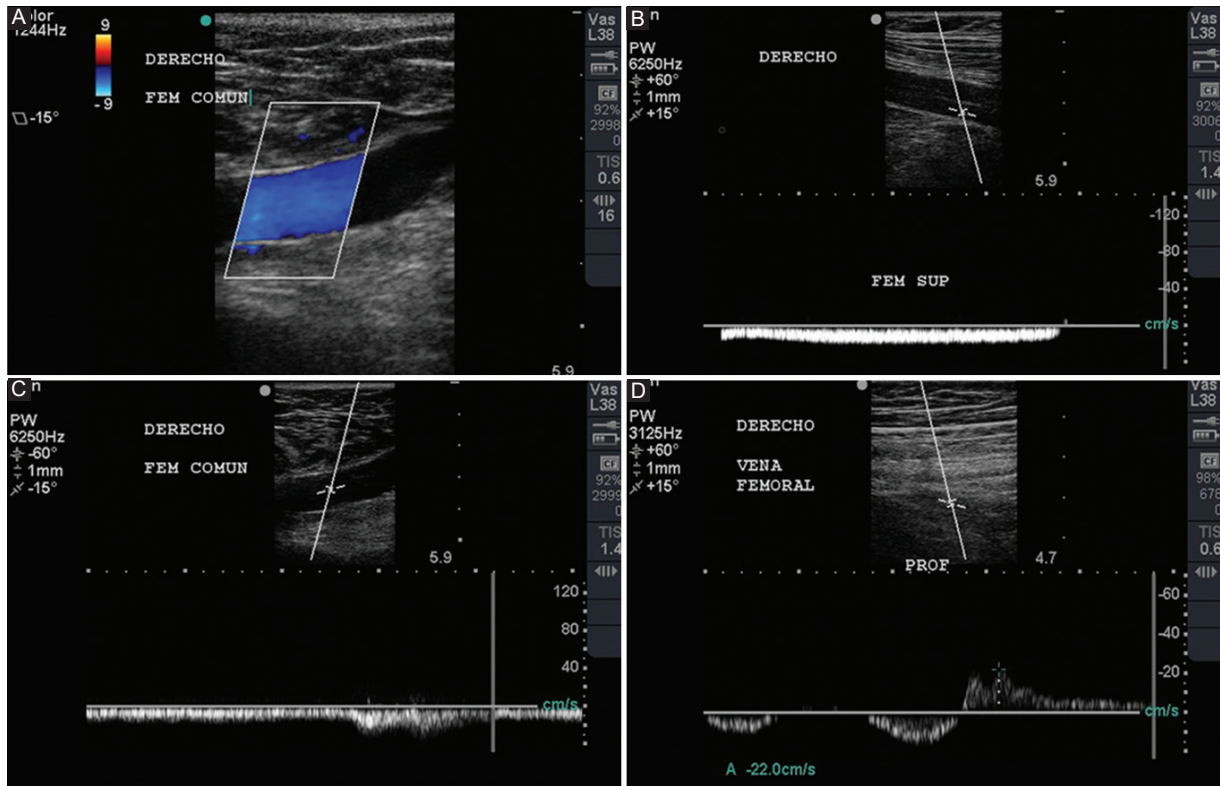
A: doppler signal with normal color; homogeneous signal with complete filling of the light of the common femoral vein, which represents permeability. B: normal pulse Doppler spectrum; the Doppler spectrum can be seen, which is respiratory phasic, below the baseline, with a small peak above the baseline due to adequate valve closure, without reflux during the Valsalva maneuver. C: muscle systole response; during the muscle systole an increase in the spectrum can be seen, without delimiting the flow, showing distal permeability with no insufficiency data. D: doppler spectrum above the baseline during the Valsalva maneuver, 22 cm/second, at least for two seconds, representing reflux due to venous insufficiency.
